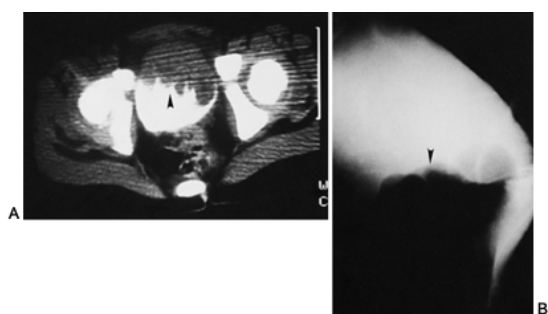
37. Computed tomography scan (A) and cystourethrogram (B) in a patient with a bladder rhabdomyosarcoma, demonstrating a filling defect in the anterior portion of the bladder (*arrowheads*).
